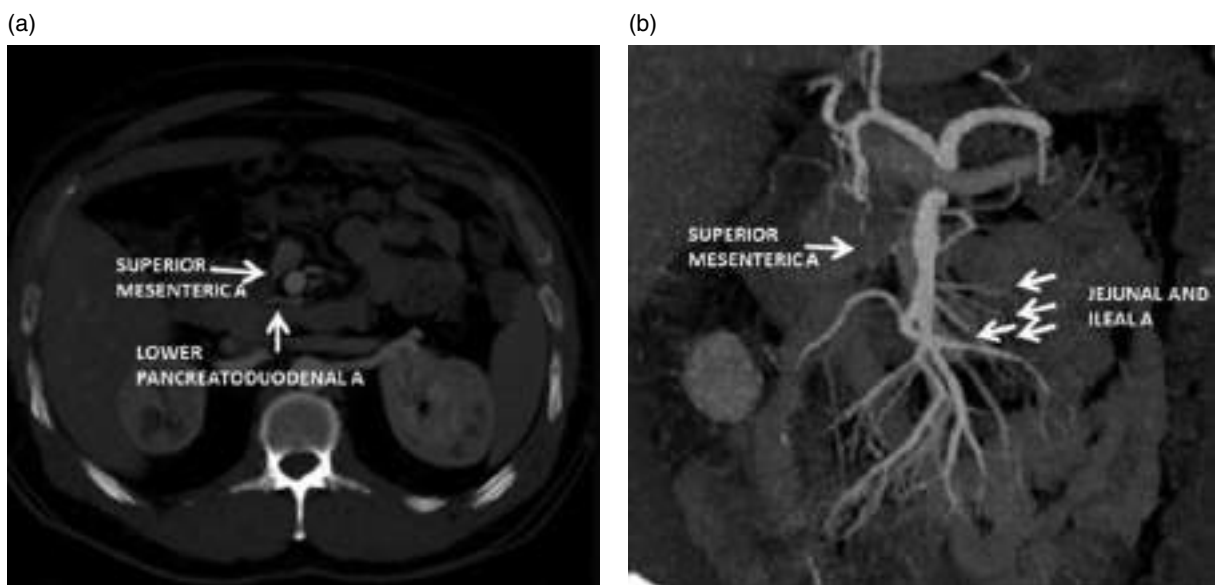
Main branches of the superior mesenteric artery. (a) Axial contrast-enhanced CT image (arterial phase). (b) Coronal contrast-enhanced MIP CT image (arterial phase).
